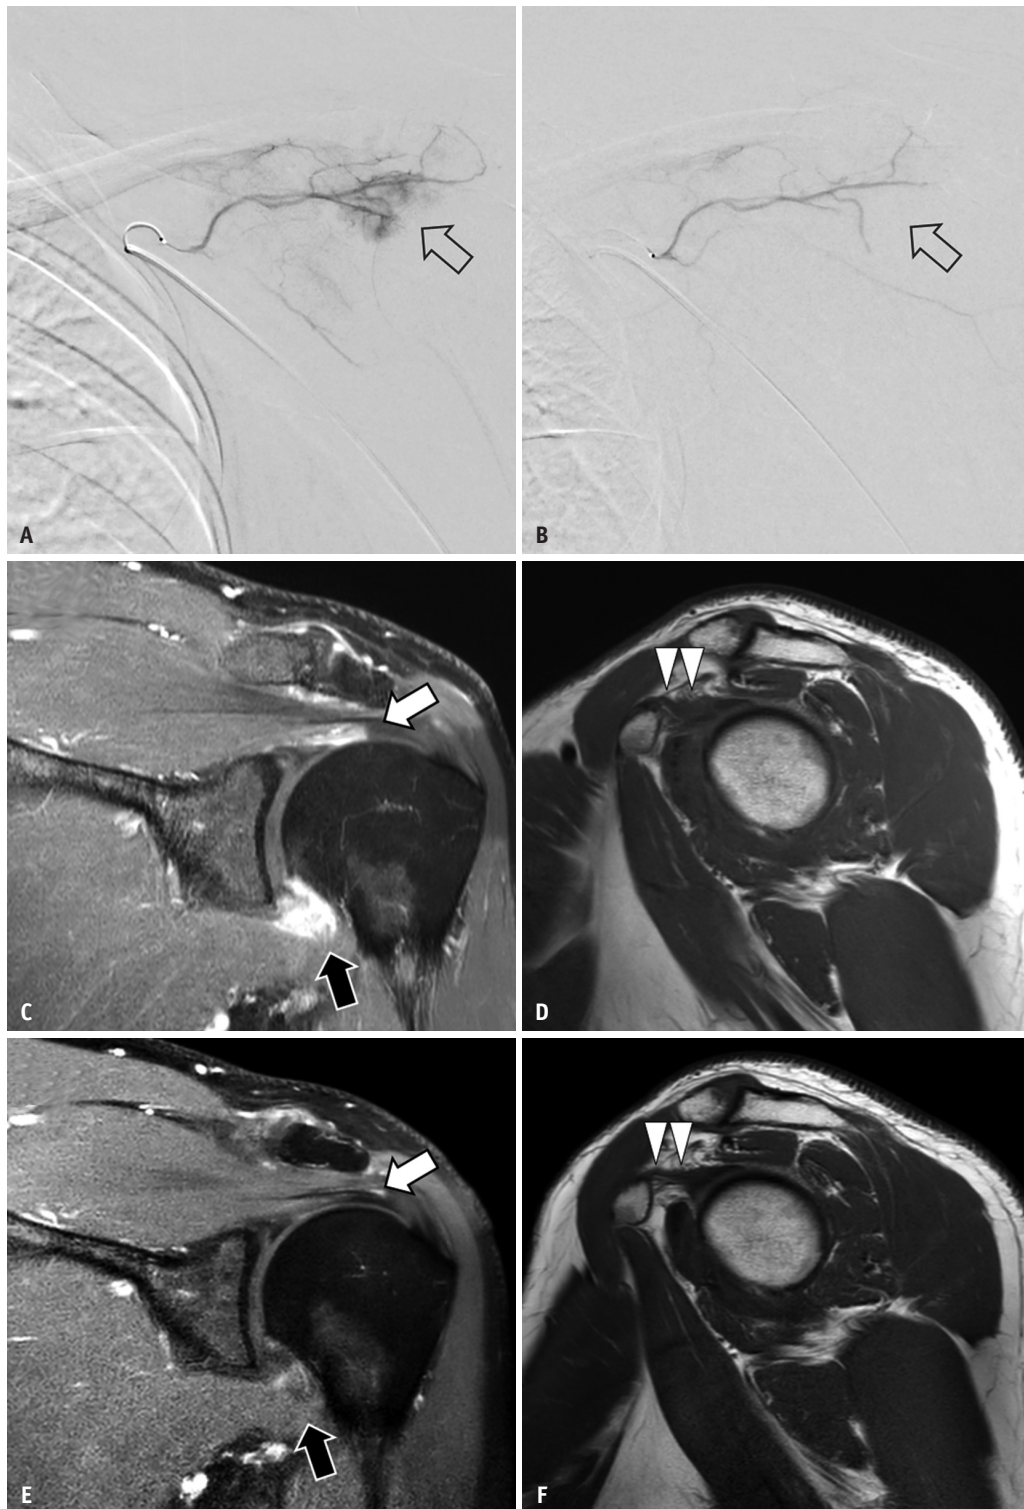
Selective angiography demonstrating successful transarterial TAE with imipenem/cilastatin for abnormal angiogenesis in a 57-year-old male patient with adhesive capsulitis in the left shoulder. A: DSA via the right thoracoacromial artery shows blush-like abnormal neo-vessel formation at the rotator interval before TAE (arrow). B: DSA via the right thoracoacromial artery demonstrates elimination of the neo-vessels after TAE (arrow). C, D: Pre-TAE MRI scans show vivid capsule enhancement (arrows, C) on oblique coronal T1-weighted fat-saturated contrast-enhanced image and fat infiltration within the rotator interval on oblique sagittal T1-weighted fat-saturated (arrowheads, D), indicative capsulitis and synovitis with inflammation and edema. E, F: Post-TAE MRI scans demonstrate significant decrease in the enhancement (arrows, E) and decrease in fat infiltrates within the rotator interval (arrowheads, F), indicating reduced infiltrates/edema. Additionally, a decrease in capsule thickness is observed in both areas. TAE = transarterial embolization, DSA = digital subtraction angiography
